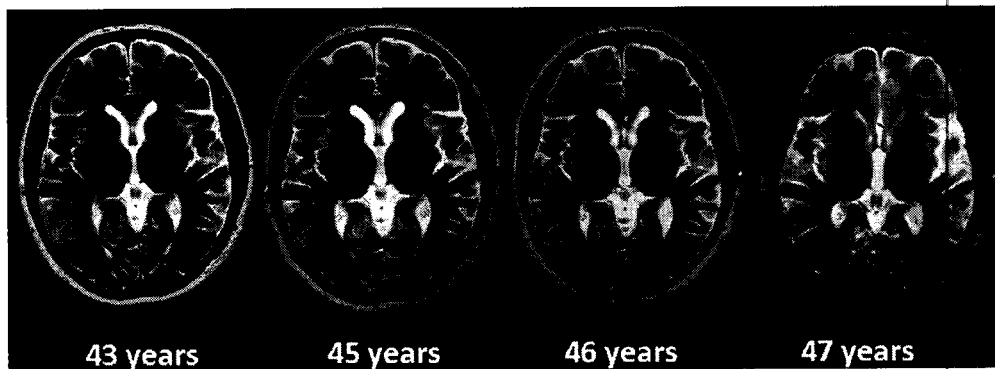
MRI of the proband (III:1): T1-weighted sequence at age 43 years, fluid-attenuated inversion recovery (FLAIR) sequence at age 45, 46 and 47 years. No signal changes are present. Specifically, the basal ganglia are normal and there is no definite focal or general atrophy.
